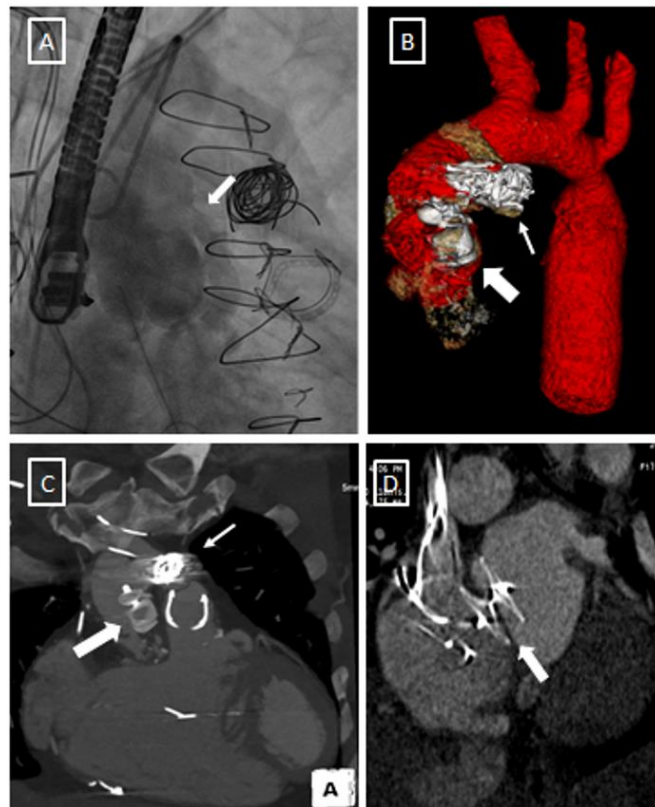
A) Angiogram showing the flow through the fistula connecting the aortic pseudoaneurysm and LVOT. B) 3D volume rendered CT showing the vascular plug (big arrow) and coil (small arrow). C) CT scan showing location of vascular plug (bit arrow) and coil (small arrow). D) CT showing location of the Amplatzer device in the intra-atrial septum (arrow).
